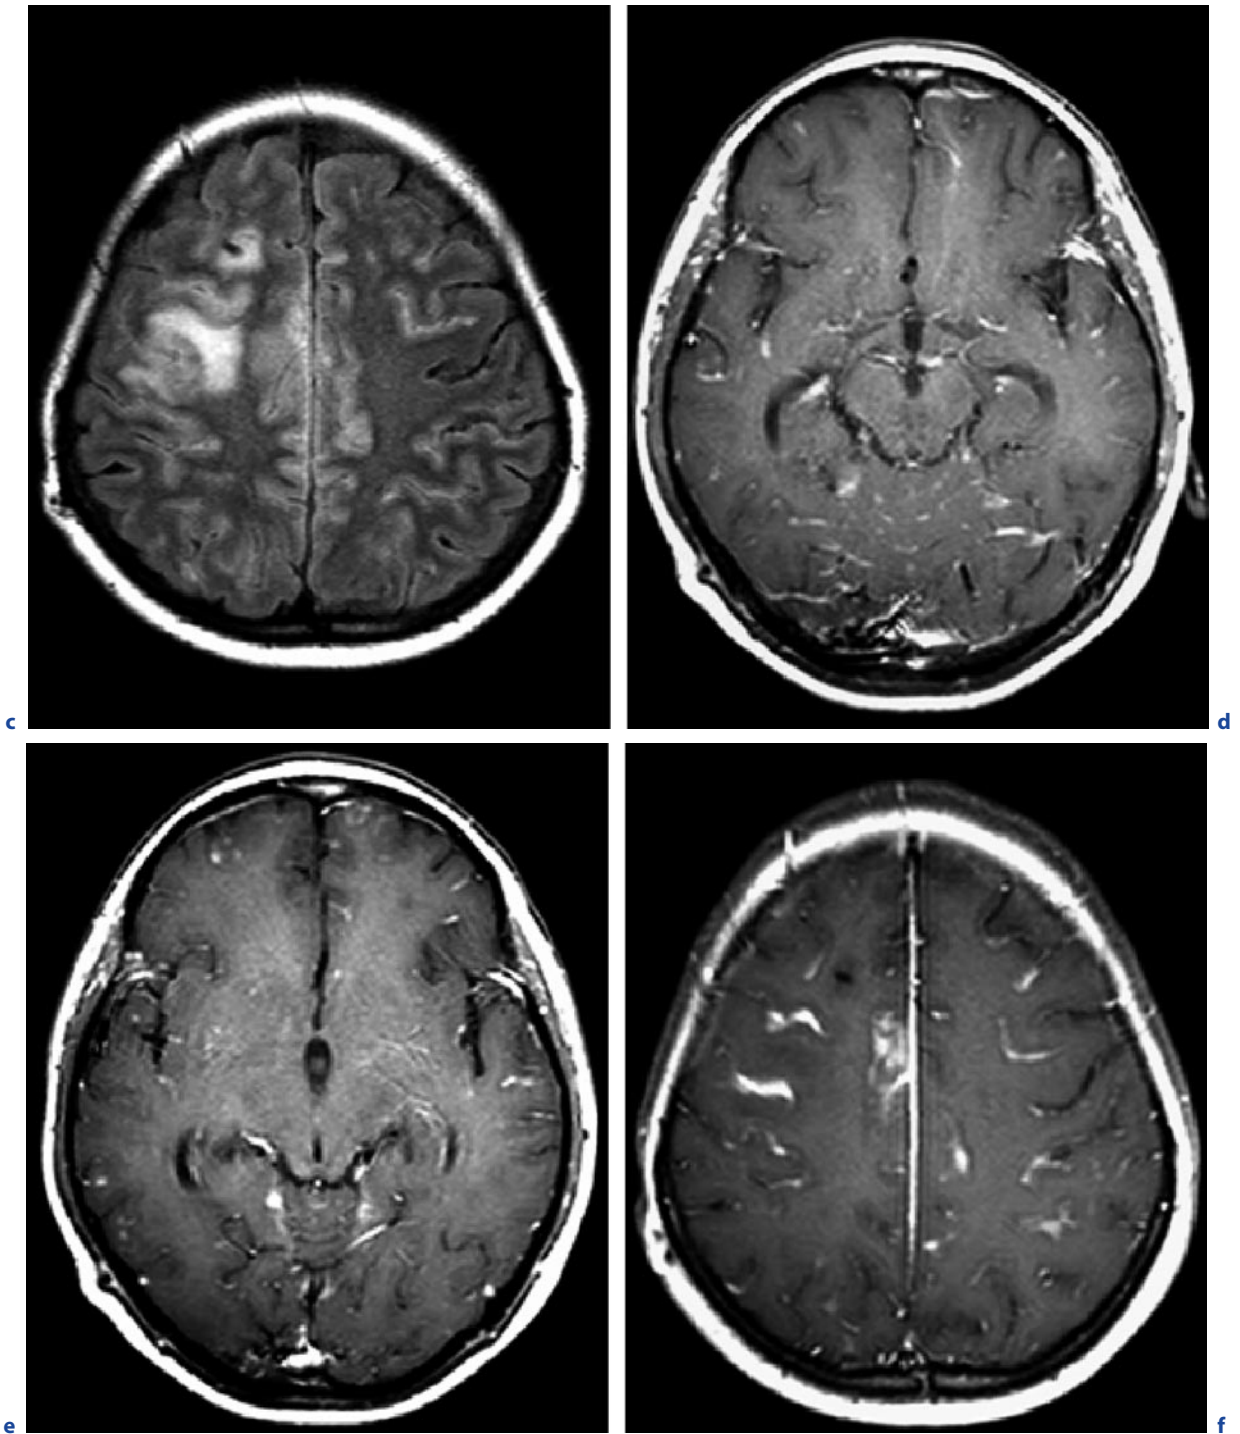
(continued) Cryptococcal leptomeningitis. c Axial FLAIR images. d,e Axial T1-weighted images after contrast administration. The parenchymal reaction may be absent in the basal sections of T2-weighted images (a) but is usually seen on FLAIR images (b,c). There is marked parenchymal
